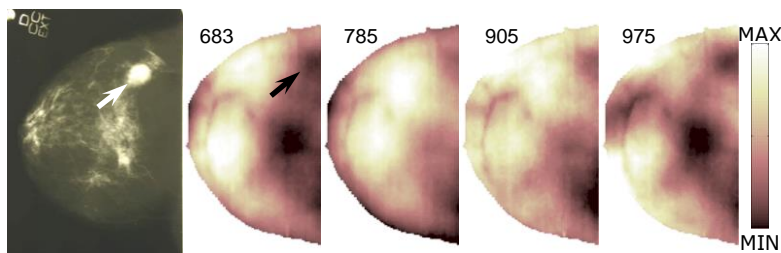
X-ray mammogram and late gated intensity images (683, 785, 905, and 975 nm) of the right breast (cranio-caudal view) of patient #180, bearing a fibroadenoma (max. diameter = 20 mm).
